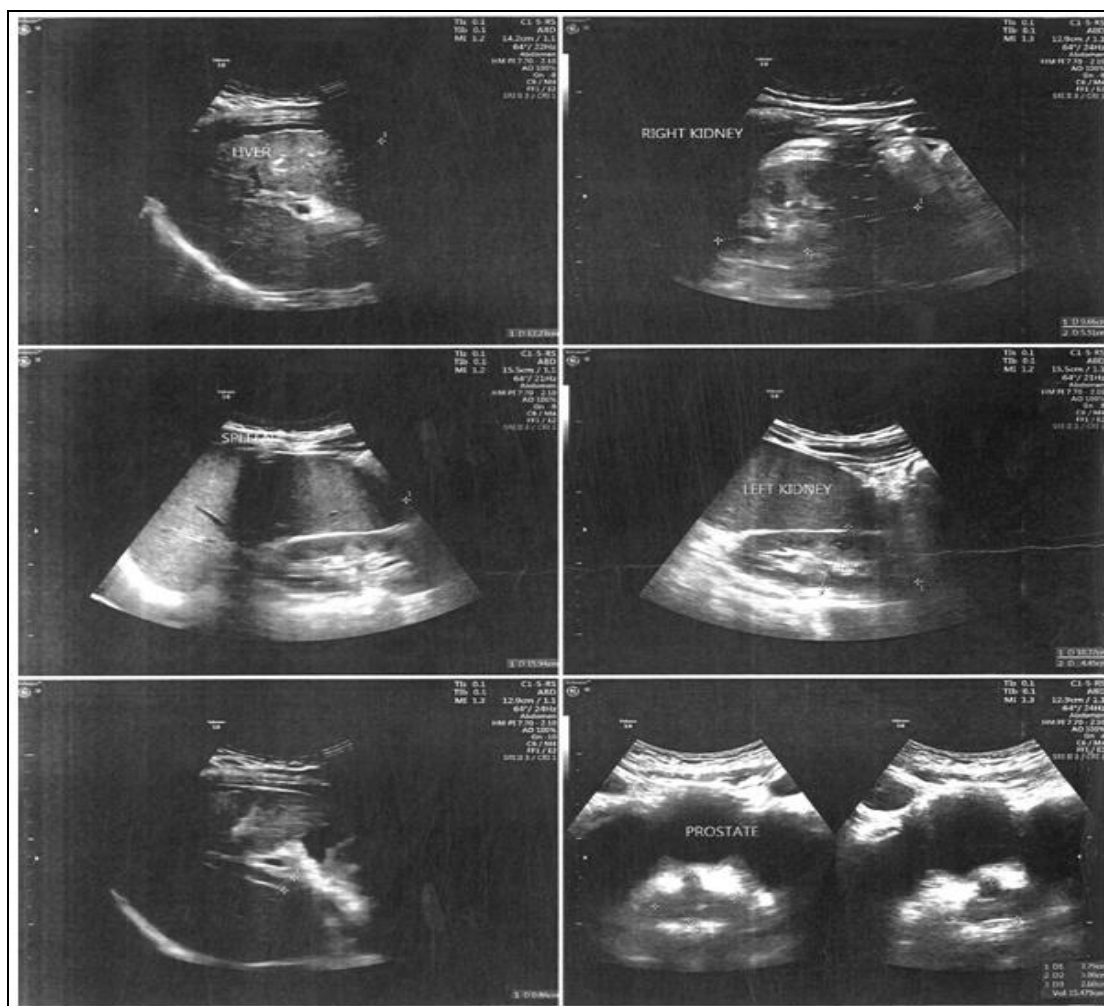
ABDOMEN AND KUB SCAN REPORT: REAL-TIME B-MODE ULTRASONOGRAPHY OF ABDOMEN AND KUB: ABDOMEN: LIVER- SIZE: 12.3 CM (NORMAL) ; ECHOTEXTURE: MILDLY ALTERED COARSE; SURFACE: IRREGULAR WITH LEFT LOBE HYPERTROPHY; PORTAL VEIN: MEASURES 8 MM AT THE LEVEL OF PORTA HEPATIS; PORTAL VEIN VELOCITY: 19 CM/S, NO PORTAL COLLATERALS; FOCAL LESION: NONE SEEN; GALL BLADDER: APPEARANCE: NORMAL; CALCULI: NONE SEEN; COMMON BILE DUCT: APPEARANCE: NORMAL; CALCULI: NONE SEEN; PANCREAS: APPEARANCE: NORMAL; SPLEEN: SIZE: MODERATELY ENLARGED, MEASURING 15.9 CM; MINIMAL ASCITES NOTED; KIDNEYS, URETERS, AND BLADDER (KUB): RIGHT KIDNEY - SIZE: 9.6 X 5.5 CM; CORTEX AND COLLECTING SYSTEM: NORMAL; CALCULI: NONE SEEN; LEFT KIDNEY: SIZE: 10.3 X 4.4 CM; CORTEX AND COLLECTING SYSTEM: NORMAL; CALCULI: NONE SEEN; CORTICAL ECHOES OF BOTH KIDNEYS: APPEARANCE: NORMAL; BLADDER: APPEARANCE: NORMAL; PROSTATE: SIZE: 3.8 X 3.0 X 2.6 CM (WEIGHT: 15.41 G); APPEARANCE: NORMAL; INTRA VESICAL ENLARGEMENT: NONE SEEN; IMPRESSION: CHRONIC PARENCHYMAL LIVER DISEASE; MODERATE SPLENOMEGALY; MINIMAL ASCITES
